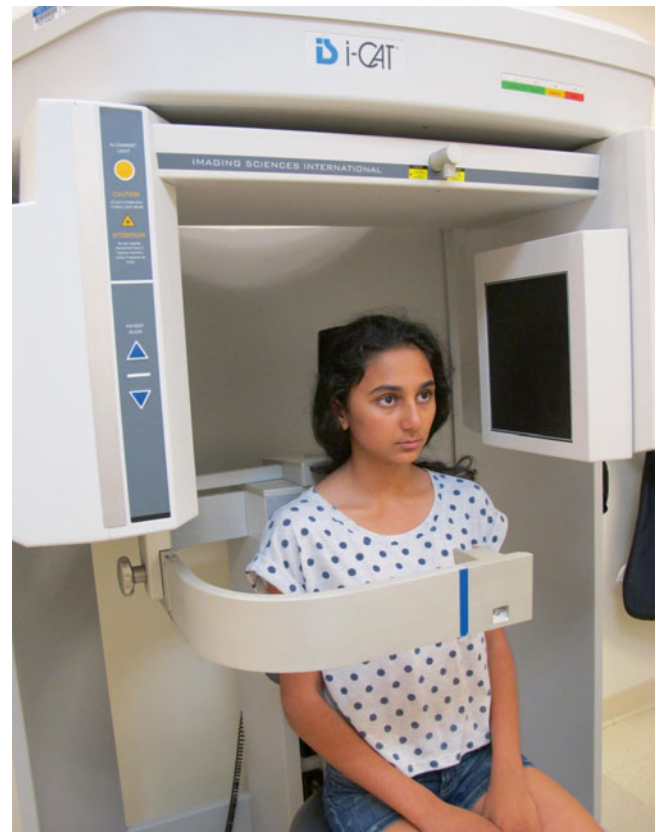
Cone beam computerized tomography (CBCT) acquisition using iCAT Next Generation system (Imaging Sciences International, Hatfield, PA). The extended view is necessary to capture the largest field of view for maxillofacial/orthognathic surgery. The patient is in an upright position unlike the recumbent positioning in medical CT scans
